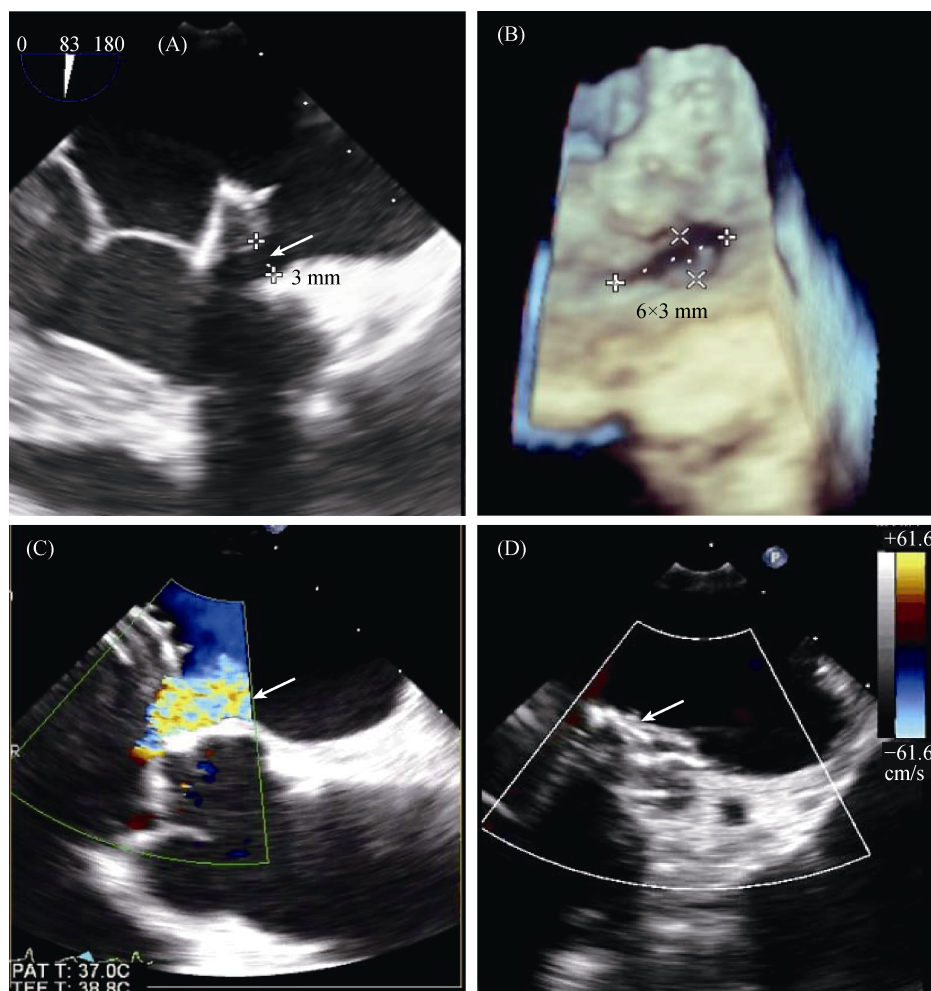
TEE images showing mitral prosthetic PVL and its sealing with occluder. (A): TEE image showing mitral prosthetic paravalvular defect (white arrow) approximately 3 mm in diameter; (B): 3D-TEE image showing the defect was approximately 6×3 mm in size and was in one o'clock position; (C): TEE color Doppler image showing mitral paravalvular regurgitation (white arrow); and (D): Intraoperative post-occluder TEE image showing the mitral PVL was sealed by ADO II (white arrow) and only minimal residual leak was observed. 3D-TEE: three-dimensional transesophageal echocardiography; ADO II: Amplatzer[®] Duct Occluder II; PVL: paravalvular leak; TEE: transesophageal echocardiography.
